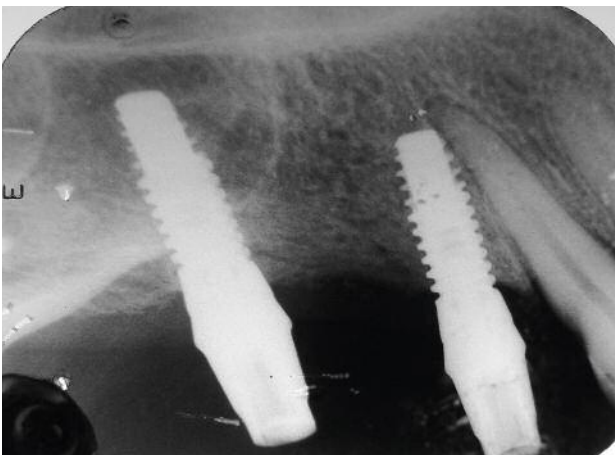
X-ray immediately after placement of the prosthetic pillars on the implants. Stability of the implant in the area of 16 was clinically proven.
